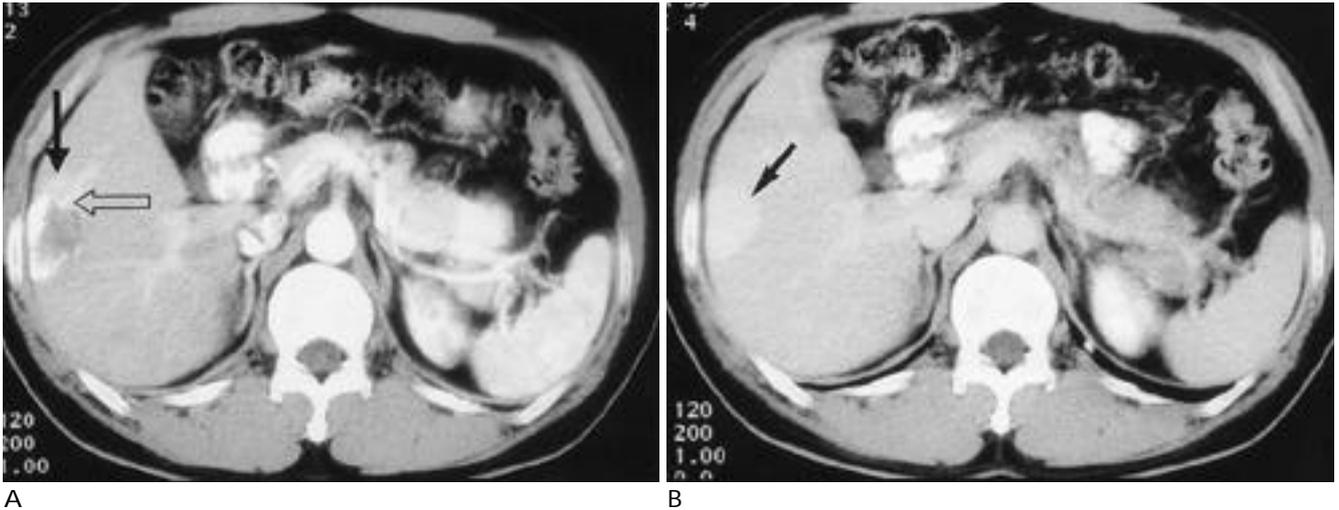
CT scan obtained in a 50-year-old man with hemangioma.
